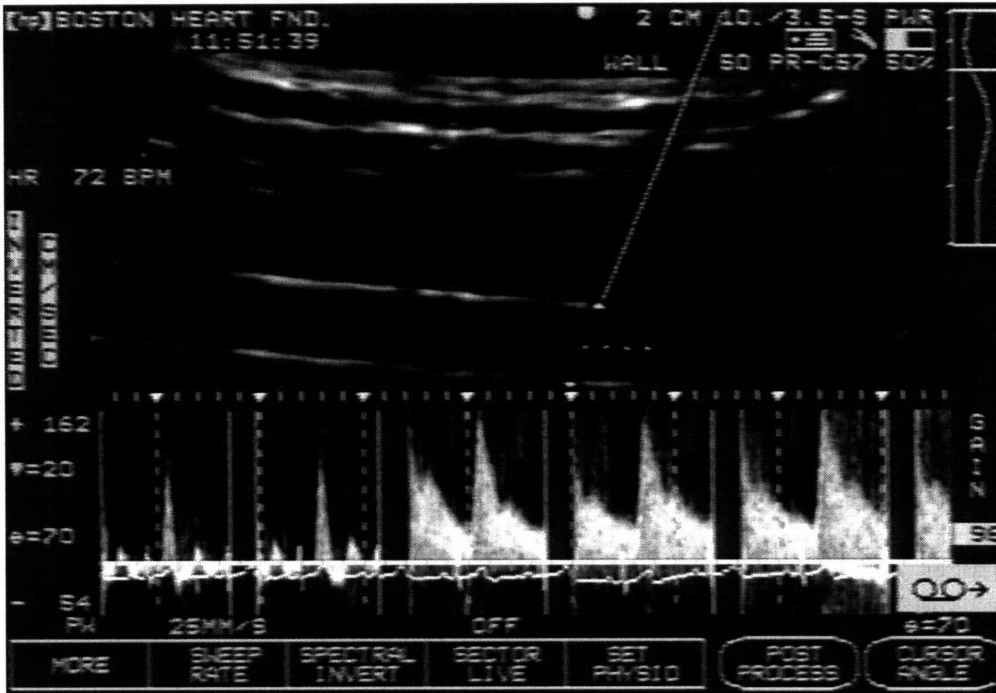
An example of the duplex imaging mode, demonstrating an end-diastolic, B-mode image of the brachial artery and pulsed-Doppler measurement of arterial flow velocity. The flow velocity tracing demonstrates the onset of reactive hyperemia after release of a 5-minute forearm vascular occlusion. Flow velocity and B-mode images are acquired during alternate cardiac cycles.
